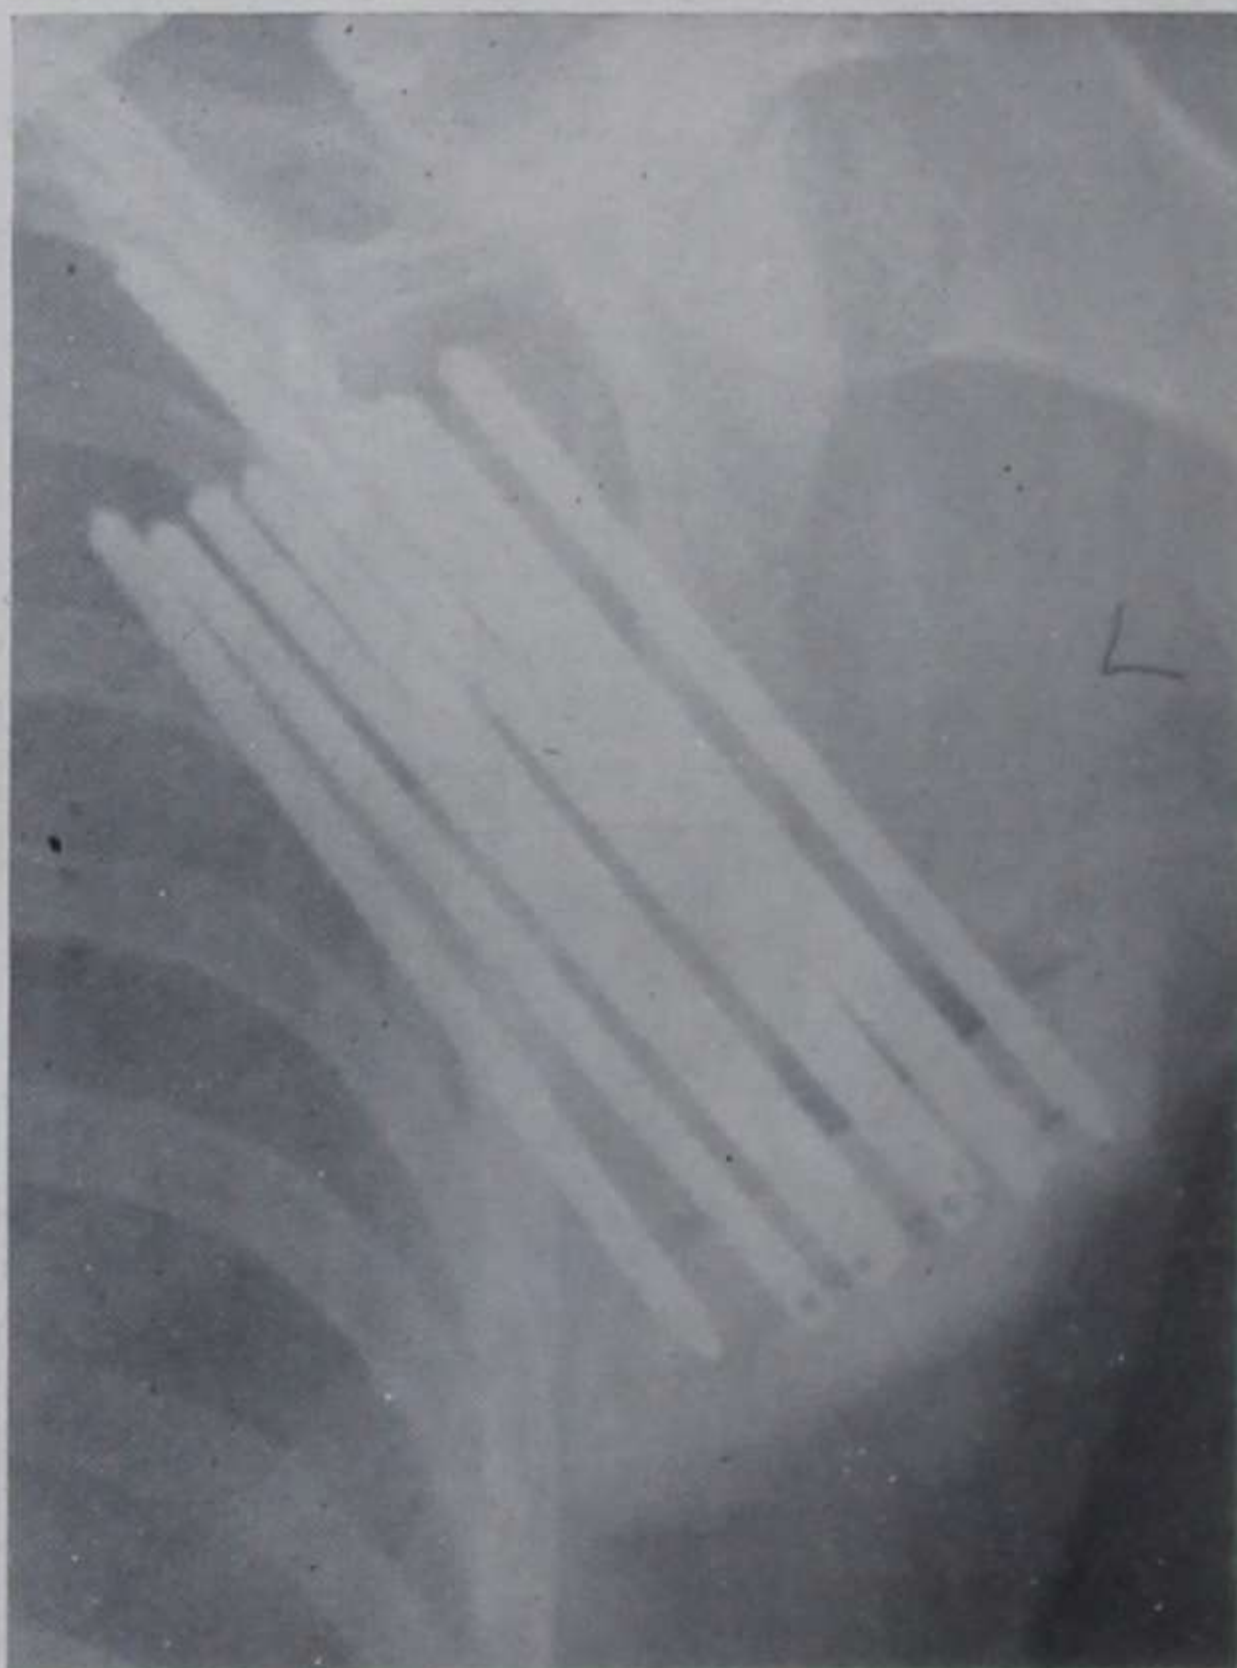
Radiograph showing radium needles in position in axilla.
